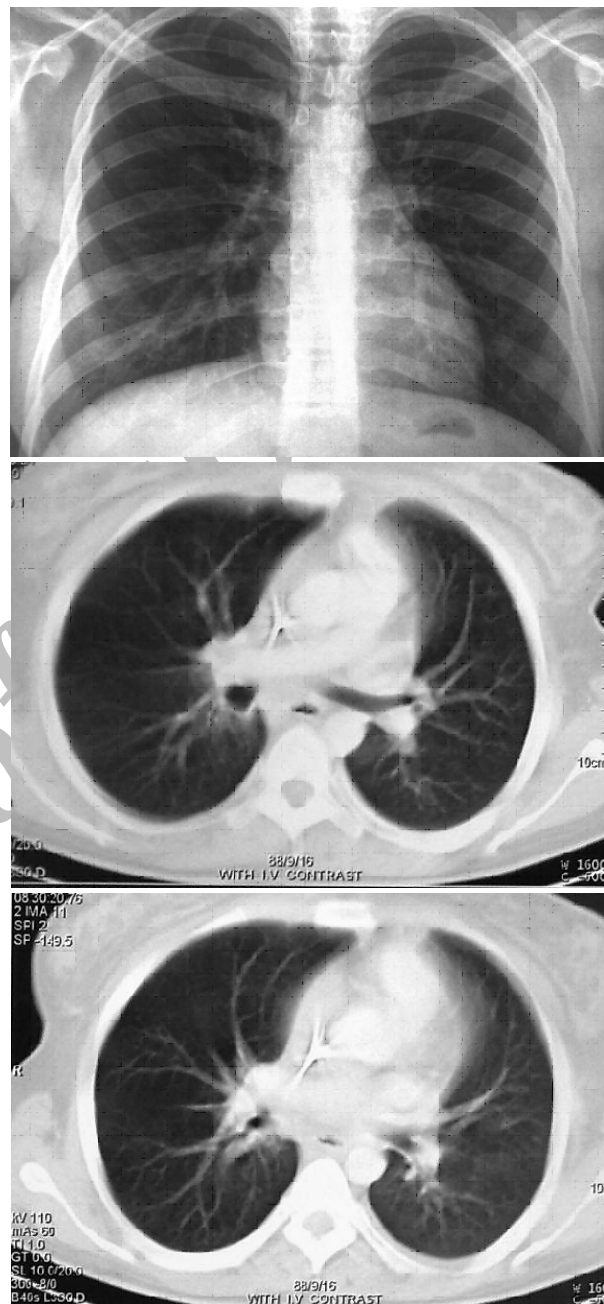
Chest x-ray and computed tomography one month after combination therapy
